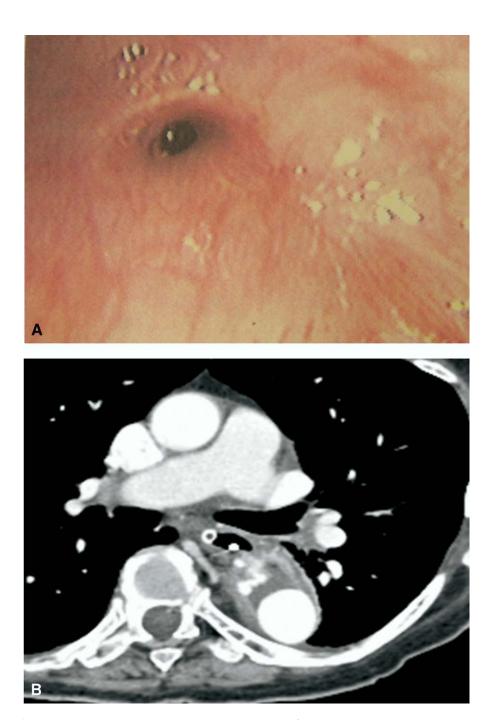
A, Endoscopic image demonstrating an aortoesophageal fistula tract in a patient who presented with hematemesis and had undergone open thoracic aortic aneurysm repair 5 years previously. B, Computed tomographic scan of the same patient demonstrating fluid collection around the aorta and contrast extravasation. The radiodense object in the esophageal lumen is a metallic clip placed at the time of endoscopy.
